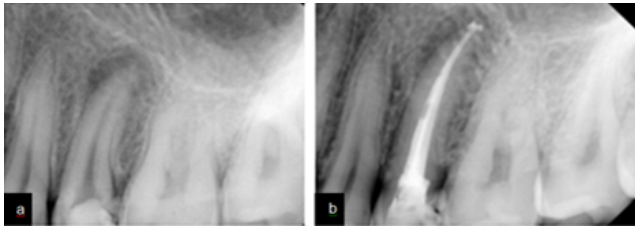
Tooth number 25 revealed presence of peri apical radiolucency at the apex of 25 and radiopacity into the pulp chamber which suggestive of temporary restoration; a: Post obturation radiograph b:
